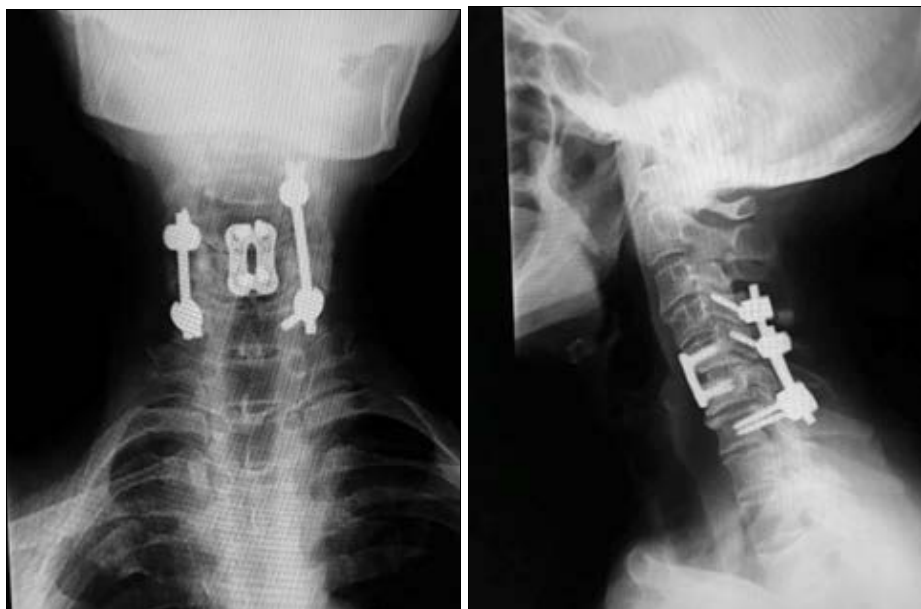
Plain x-ray imaging six months after surgery
